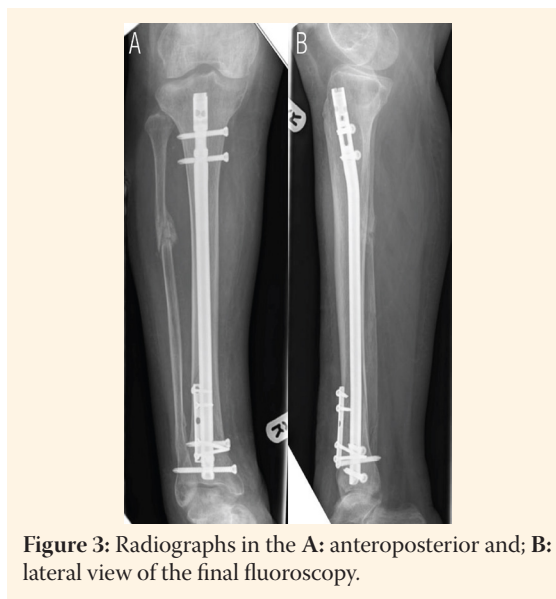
Radiographs in the A: anteroposterior and; B: lateral view of the final fluoroscopy.
